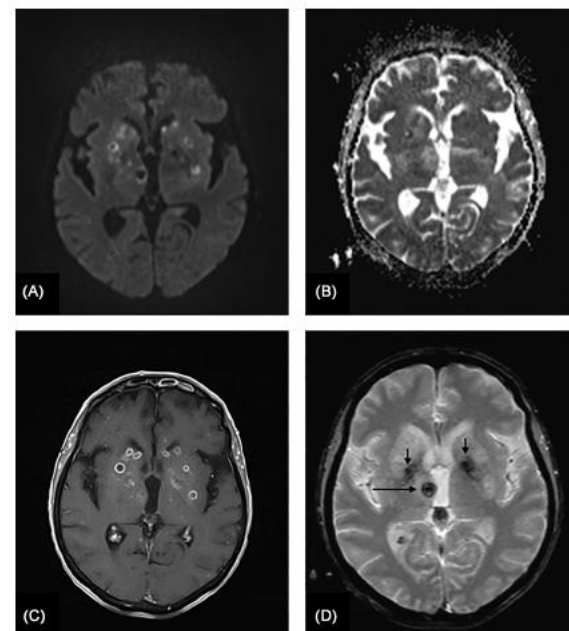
MRI of a patient with disseminated infection without IE during neutropenia. (A) Diffusion Weighted Imaging (DWI) (with b-values of 1000 s/mm²) and (B) ADC cartography show multiple micro and macro abscesses in the corpus callosum with a variable diffusion signal and cartography ADC value. (C) A micro-abscesses enhance on gadolinium-enhanced 3DT1-weighted image. (D) Axial T2* Image shows micro-abscess hemorrhagic phenomena (black arrow) and basal ganglia common calcifications (black arrowhead).
